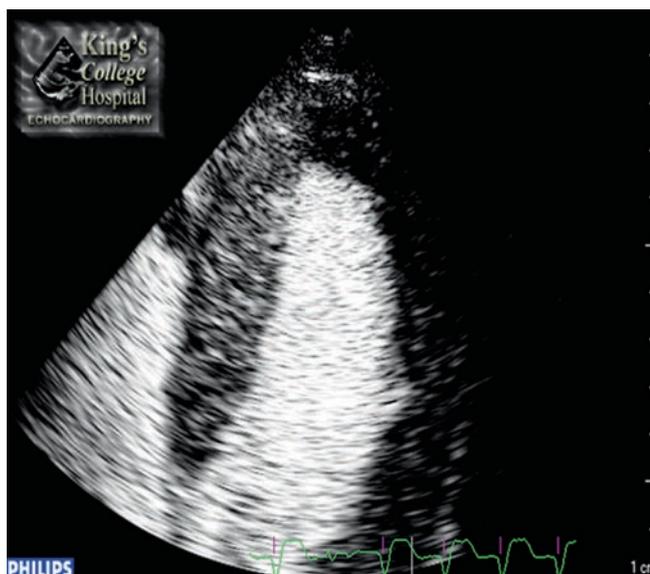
Contrast-enhanced apical 4-chamber view at peak dobutamine stress in a patient with a 95% left circumflex lesion. The still image is taken at two cardiac cycles post-destruction. The septum has fully replenished, whereas the lateral wall has not, indicating reversible ischaemia in this territory. The video clip shows a stress induced wall motion abnormality seen (with contrast enhancement) in the lateral wall together with a persisting perfusion defect post-destruction
